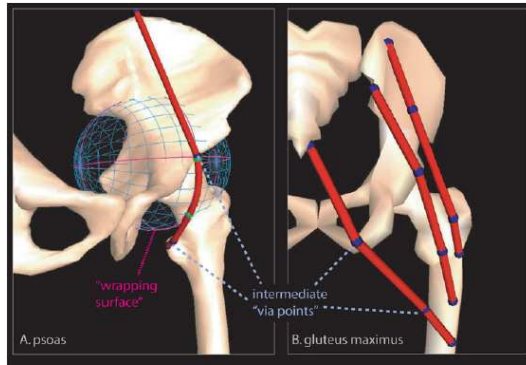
MRI-based action-lines, wrapping surfaces and via-points reconstruction, from Arnold et al. [ASAD00]
